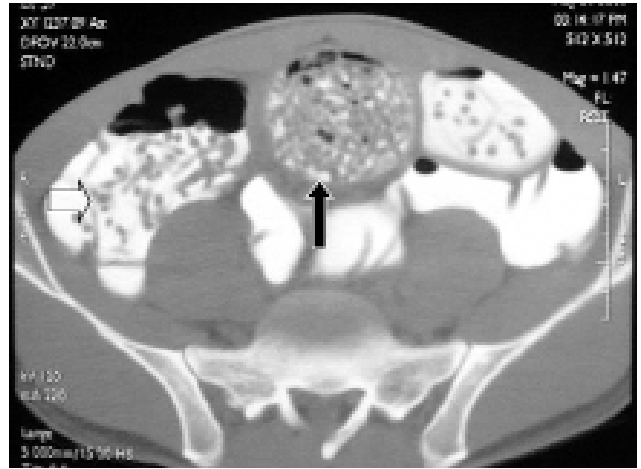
Abdominal CT scan following the gastrografin study showing the small bowel loaded with *Ascaris* worms (black arrow), while there were fewer worms in the right colon (open arrow). There was no free air in the peritoneal cavity.
